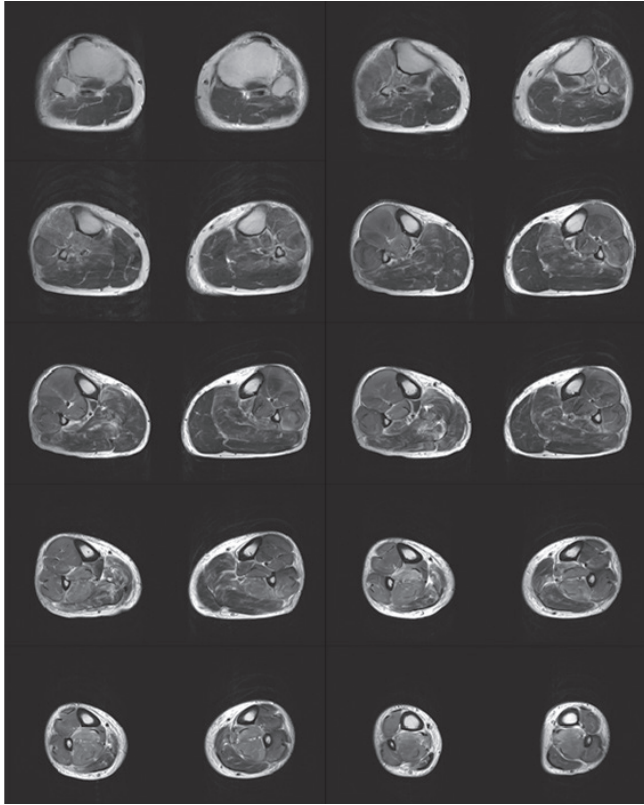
T2-weighted magnetic resonance imaging of the lower extremities in the late phase. The anterior, lateral, and deep posterior compartments of both calf muscles are swollen, and the signal intensity is increased. Inner compartment enhancement is not observed, but the fascia rim is enhanced. The superficial posterior compartment shows mild swelling, and signal intensity is increased heterogeneously. There is patchy enhancement in the superficial posterior compartment.
